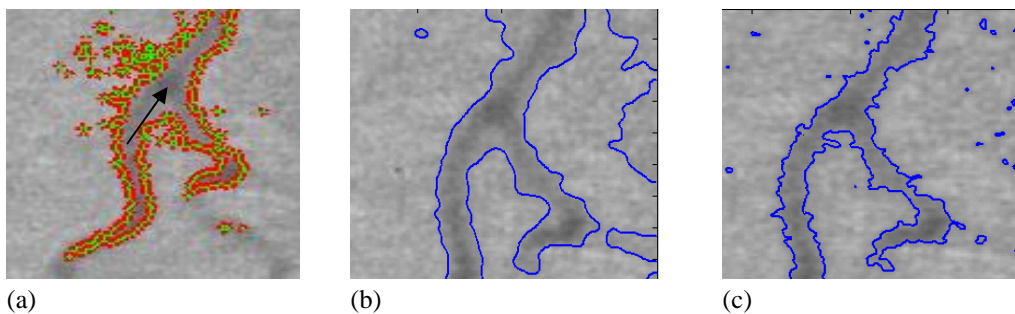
Experiments on X-ray images of thin and winding blood vessels. The final results using the C-V, SGLACM, and proposed methods are shown in the first, second, and third columns, respectively. The parameter of $\alpha=0.06$ and $\sigma = 3$.
